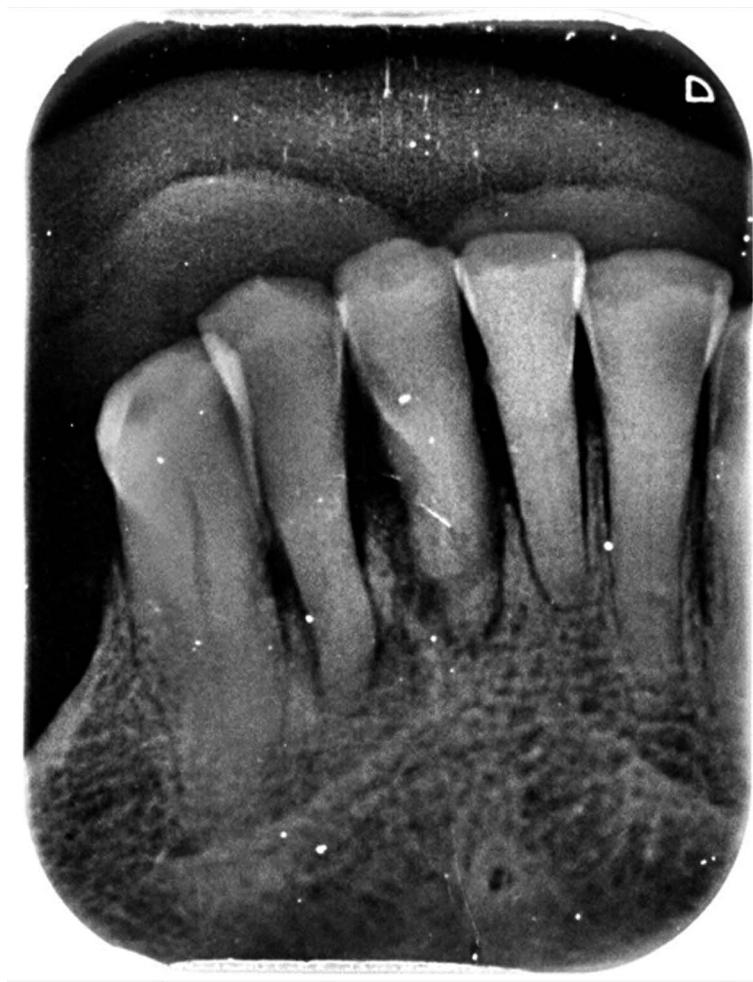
Periapical radiograph showing radiolucent areas with loss of cortical bone continuity
